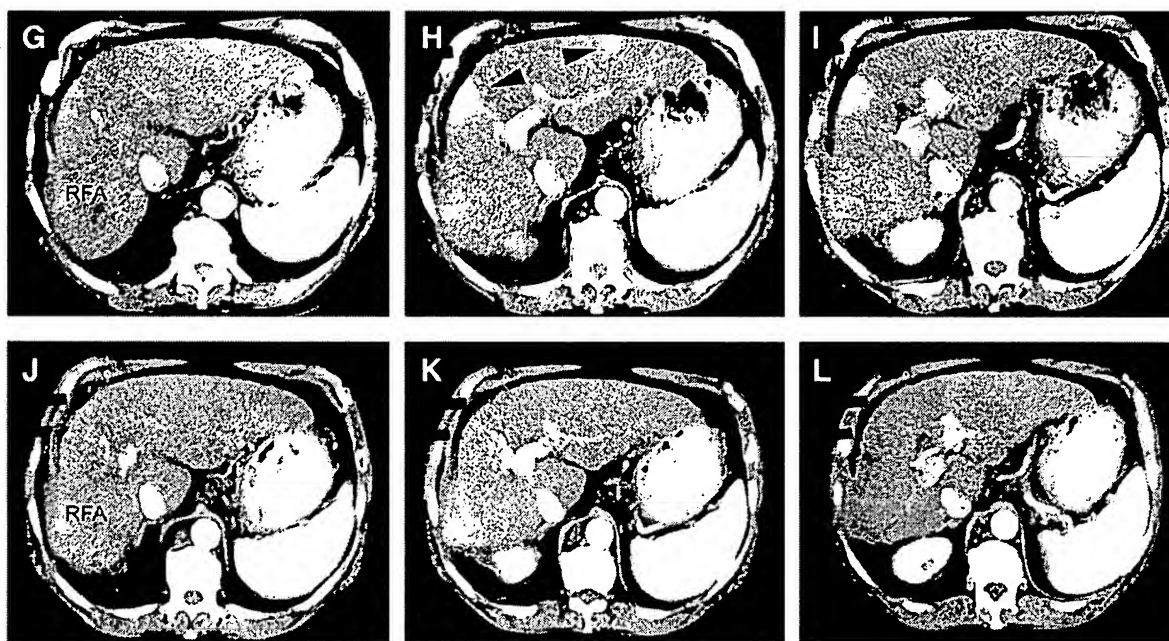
Computed tomography scans showing the effects of arginine deiminase conjugated to polyethylene glycol (ADI-SS PEG 20,000 mw) on hepatocellular carcinoma (arrows) in two patients with radiologic complete response. Upper three computed tomography panels for each patient, pretreatment; lower three panels, after three cycles of treatment. RFA, radiofrequency ablation.
